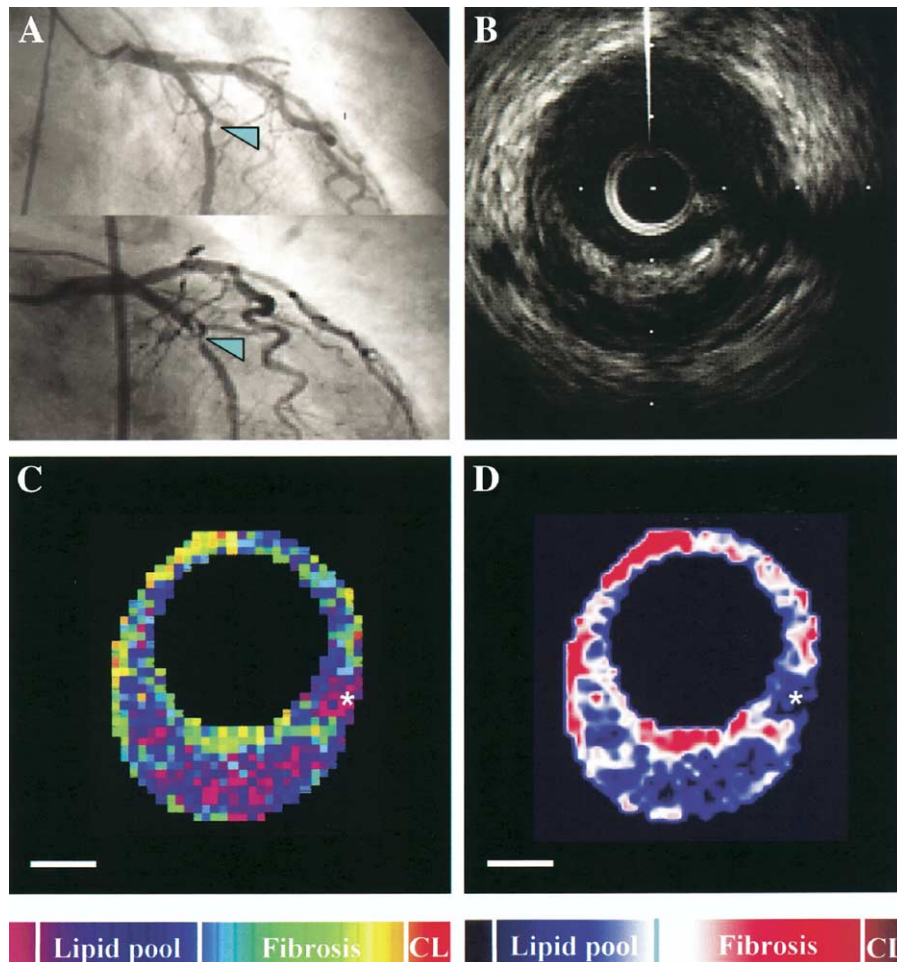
Images of the culprit lesion causing acute coronary syndrome. (A) Angiography of the circumflex coronary artery. (Upper) The arrowhead indicates a lesion, in which IVUS measurements were recorded at baseline. (Lower) The arrowhead indicates the culprit lesion at follow-up. (B) Conventional intravascular ultrasound (IVUS) image of the segment indicated by the arrowhead in A. (C) Integrated backscatter (IB)-IVUS image of Cartesian coordinates, constructed using conventional color gradation, of the segment indicated by the arrowhead in A. The asterisk indicates the guidewire artifact. Note the large lipid core (blue) with fibrous cap (green). (D) IB-IVUS image of Cartesian coordinates, constructed using another color gradation, of the segment indicated by the arrowhead in A. The asterisk indicates the guidewire artifact. Note the large lipid core (blue) with fibrous cap (red or white). CL = calcification. Bar = 1 mm.
